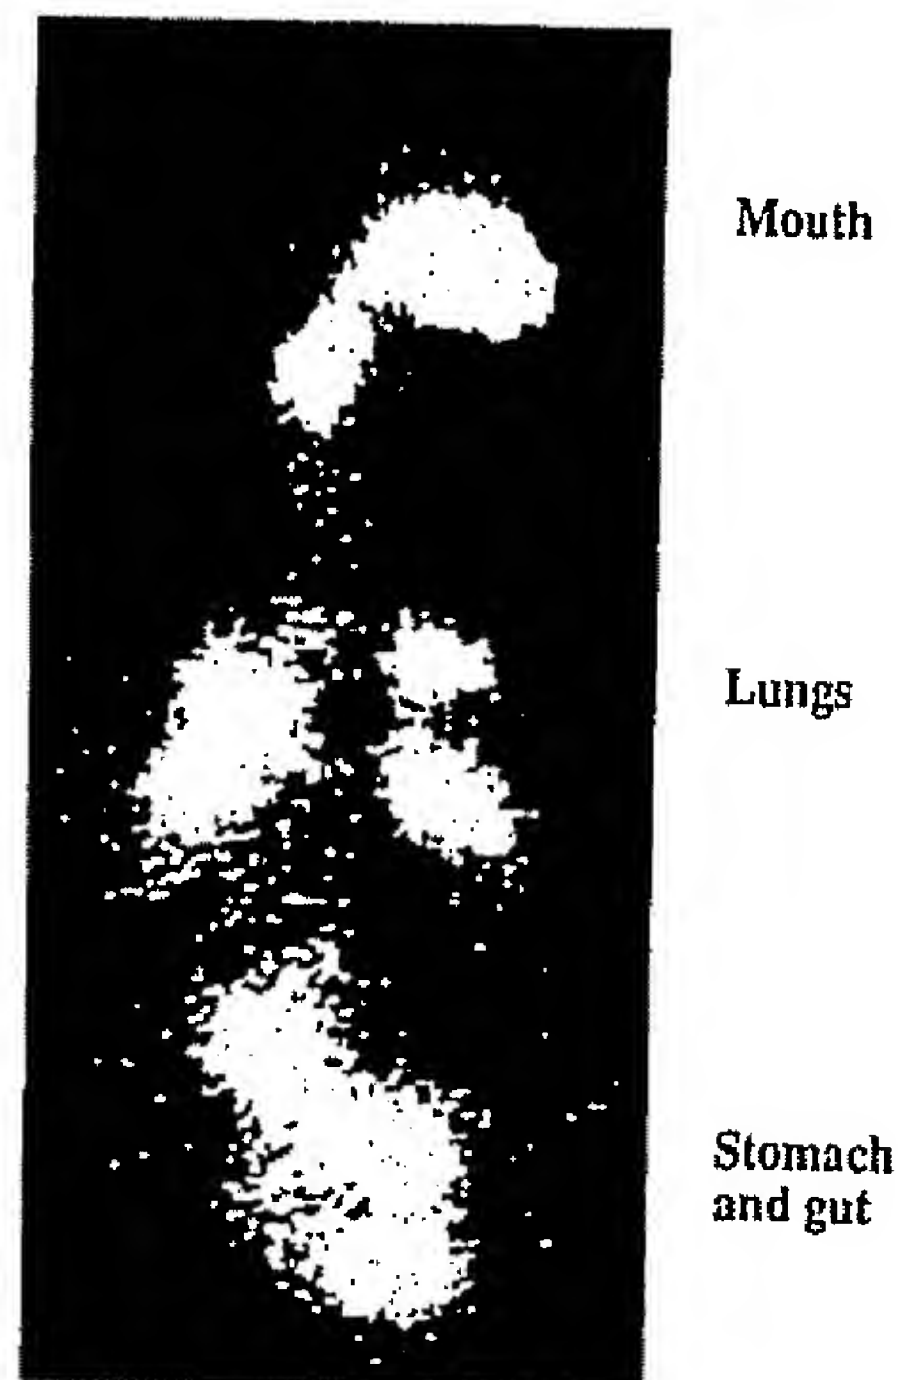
Gamma camera scintigraphy of deposition following use of a pressurized MDI in a human subject (Newman et al., 1981).
